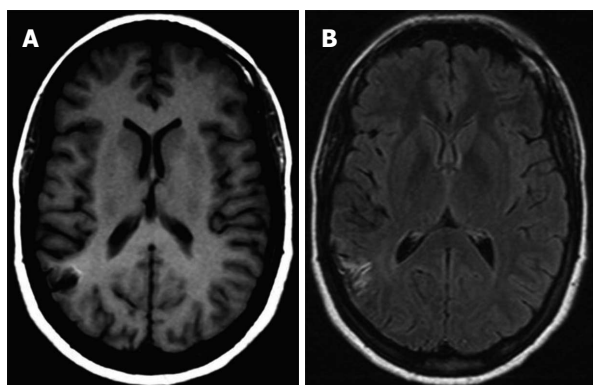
Magnetic resonance imaging at 18-mo follow-up. Axial T1-weighted (A) and fluid-attenuated inversion-recovery sequences (B). Faint hyperintense cortical laminar lesion is still present.
